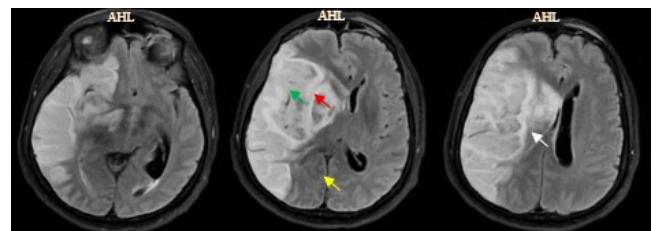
Head MRI 24 hours after onset. Wedge-shaped lesion in the cortical subcortical regions of the right frontotemporoparietal lobe (white arrow), right basal ganglia (yellow arrow), right external capsule (red arrow), and right insula (green arrow), corresponding to the right MCA territory
